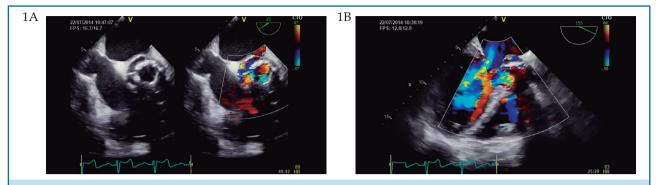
Mid-esophageal view of transesophageal echocardiography showing aortic biological prosthesis in a short axis with partial displacement of the prosthetic ring (figure 1A). Aortic biological prosthesis in a long axis view with severe paravalvular leak (figure 1B). To view the video click on the link: http://publicacoes.cardiol.br/portal/ijcs/ingles/videos/2019-0138/2019-0138.asp).
